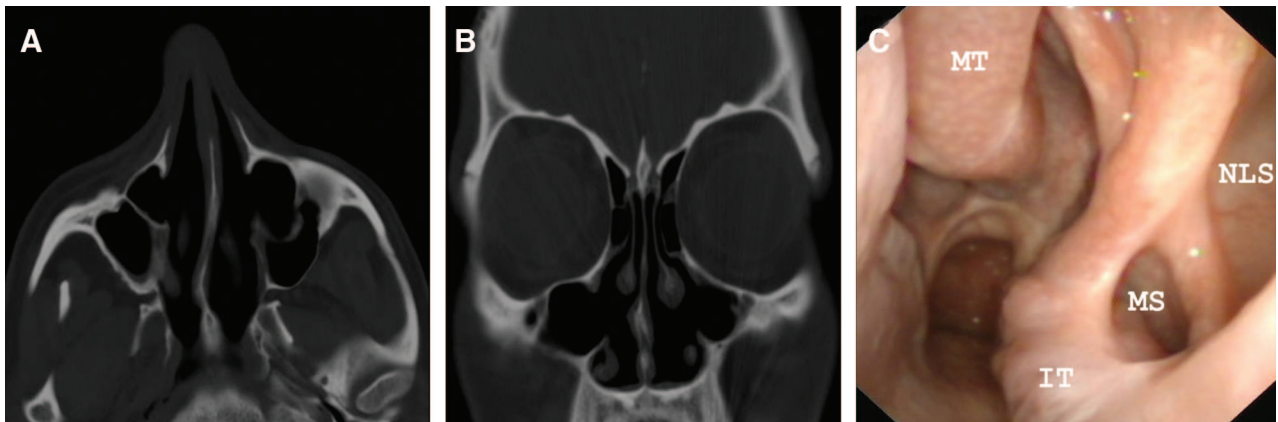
Case 1. A, Axial CT shows marsupialization and enlargement of both dacryocystoceles. B, Coronal CT shows bilateral wide middle meatal antrostomy. C, During left nasal endoscopy, note the permeability of the nasolacrimal duct and maxillary sinus.
